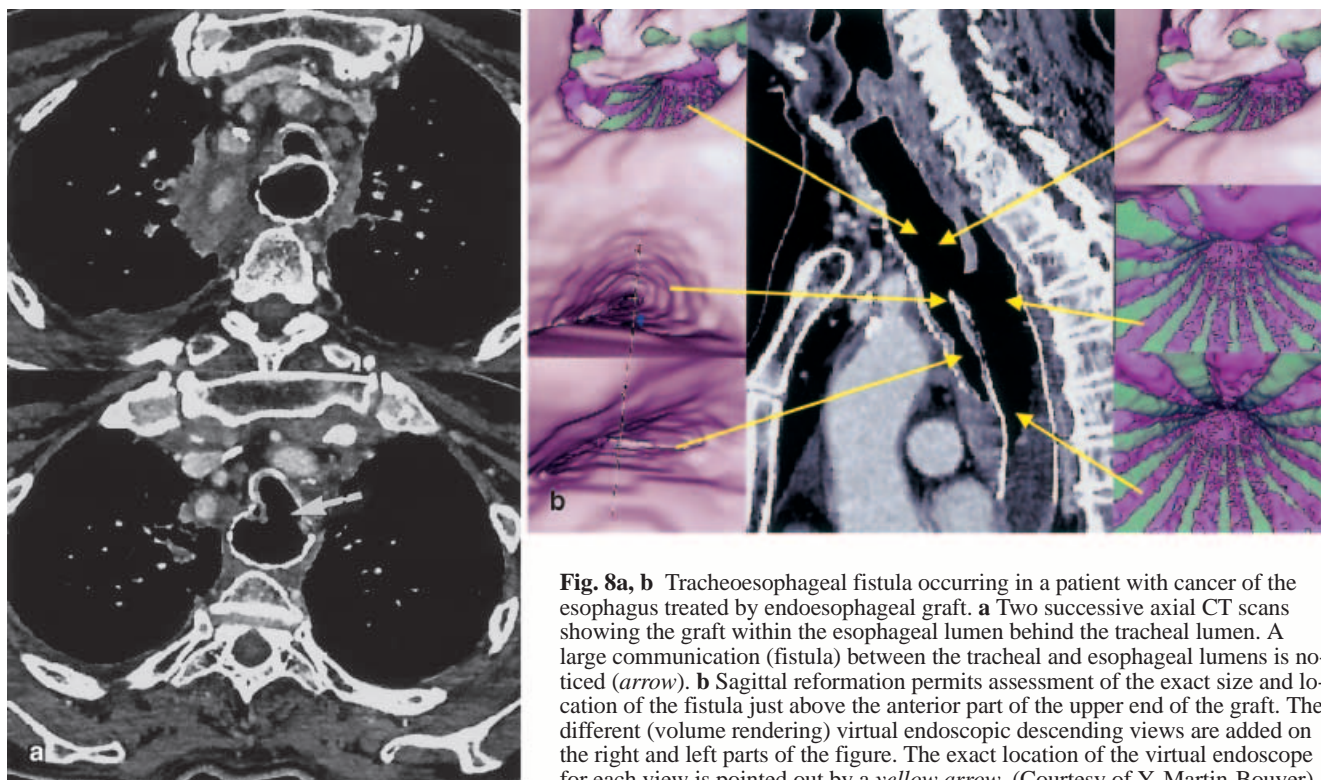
Tracheoesophageal fistula occurring in a patient with cancer of the esophagus treated by endoesophageal graft. a Two successive axial CT scans showing the graft within the esophageal lumen behind the tracheal lumen. A large communication (fistula) between the tracheal and esophageal lumens is noticed (*arrow*). b Sagittal reformation permits assessment of the exact size and location of the fistula just above the anterior part of the upper end of the graft. The different (volume rendering) virtual endoscopic descending views are added on the right and left parts of the figure. The exact location of the virtual endoscope for each view is pointed out by a *yellow arrow*. (Courtesy of Y. Martin-Bouyer)
